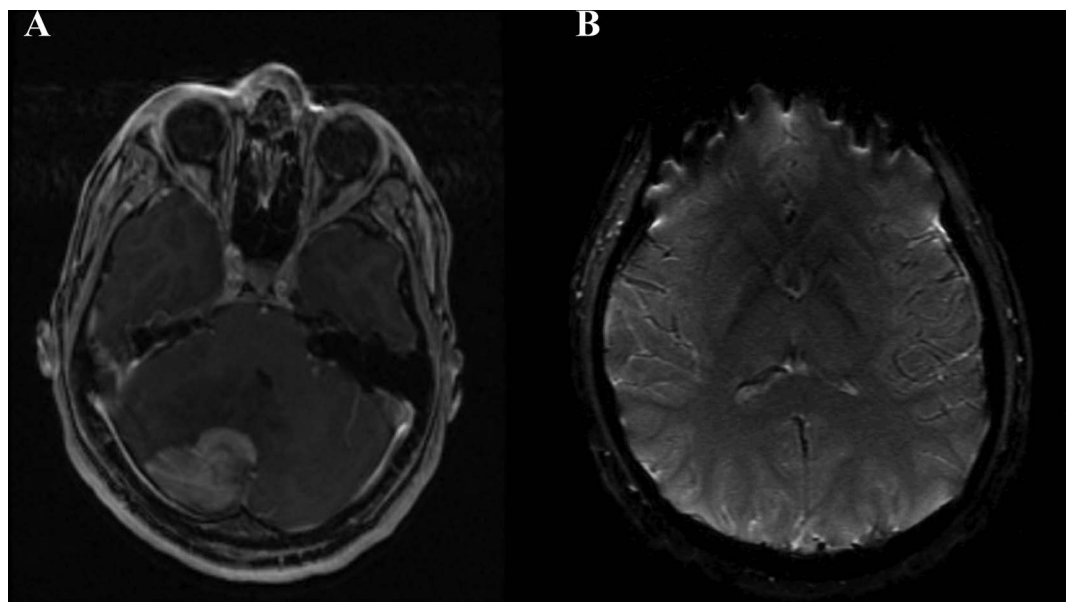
MRI characteristics of primary central nervous system lymphoma at presentation reveals contrast-enhancing cerebellar tumour on post gadolinium sequences (A) and no evidence of prior basal ganglia abnormalities on susceptibility-weighted sequences (B).
